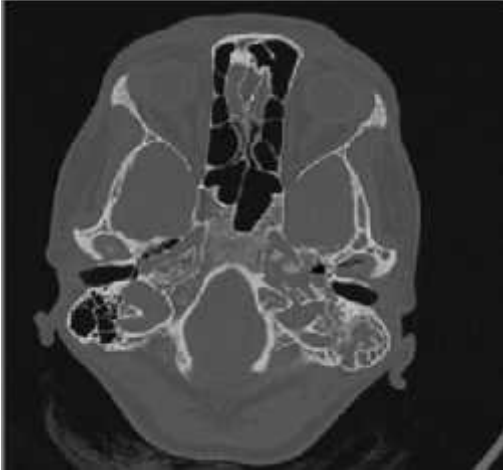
HRCT axial image bone window shows erosion and widening of left petrous apex (arrow) and part of left clivus.
